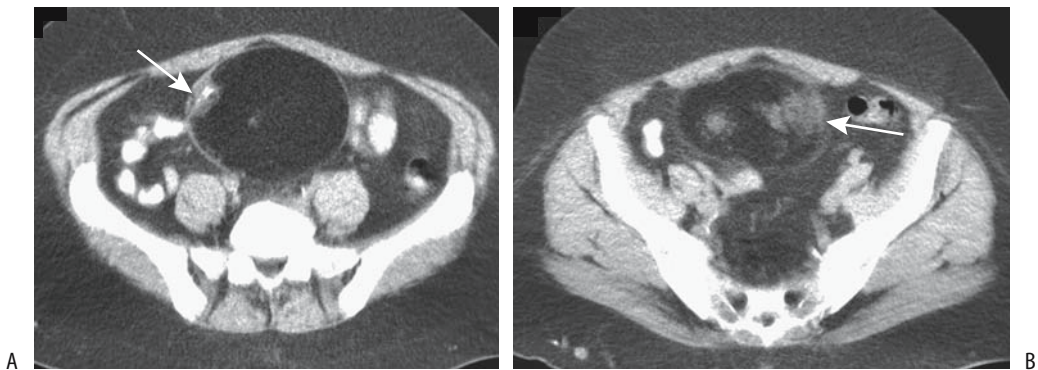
Cystic teratoma. A: CT detects a large, midline mostly fat density tumor containing a bone fragment (arrow) and encased by a thin capsule. B: A slightly more inferior image identifies soft tissue nodules (arrow). (Courtesy of Egle Jonaitiene, M.D., Kaunas Medical University, Kaunas, Lithuania.)
